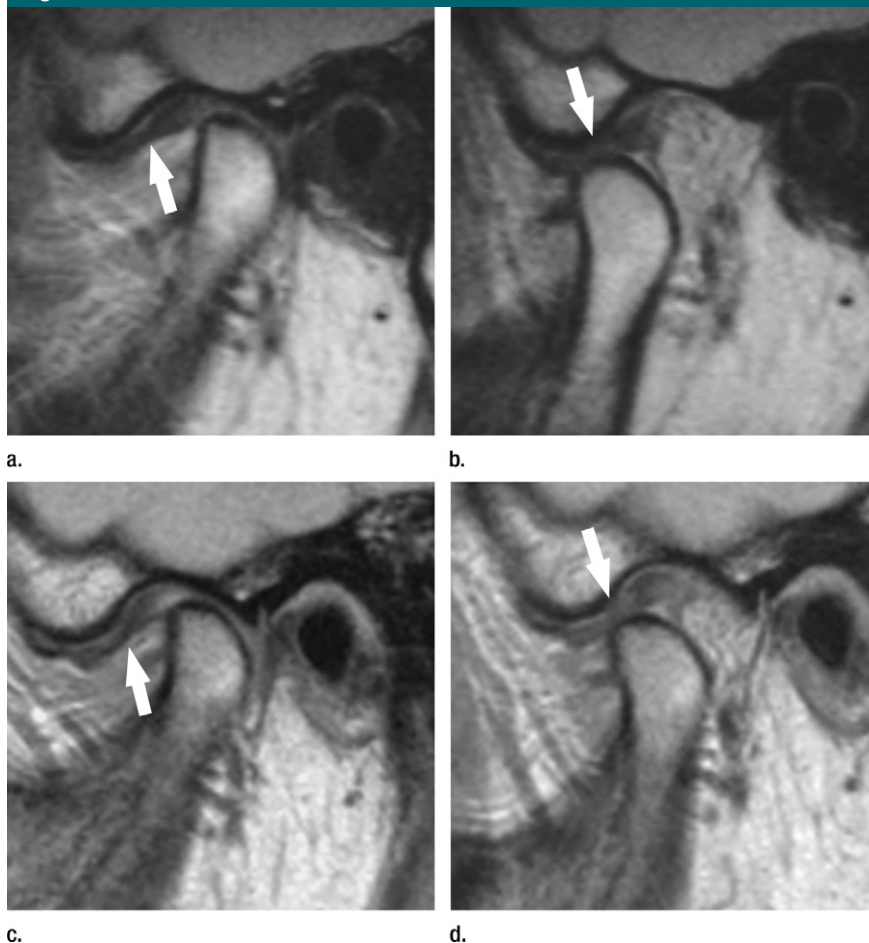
MR images of anterior TMJ disk displacement with reduction (arrow) at inception and at 15-year follow-up in a 37-year-old woman (22 years old at study inception). Proton density-weighted sagittal images (2199/17) were obtained in (a) closed-mouth and (b) open-mouth position at inception and (c) closed-mouth and (d) open-mouth position at 15-year follow-up (2300/13). Note maintained TMJ disk position and bone status at follow-up.
